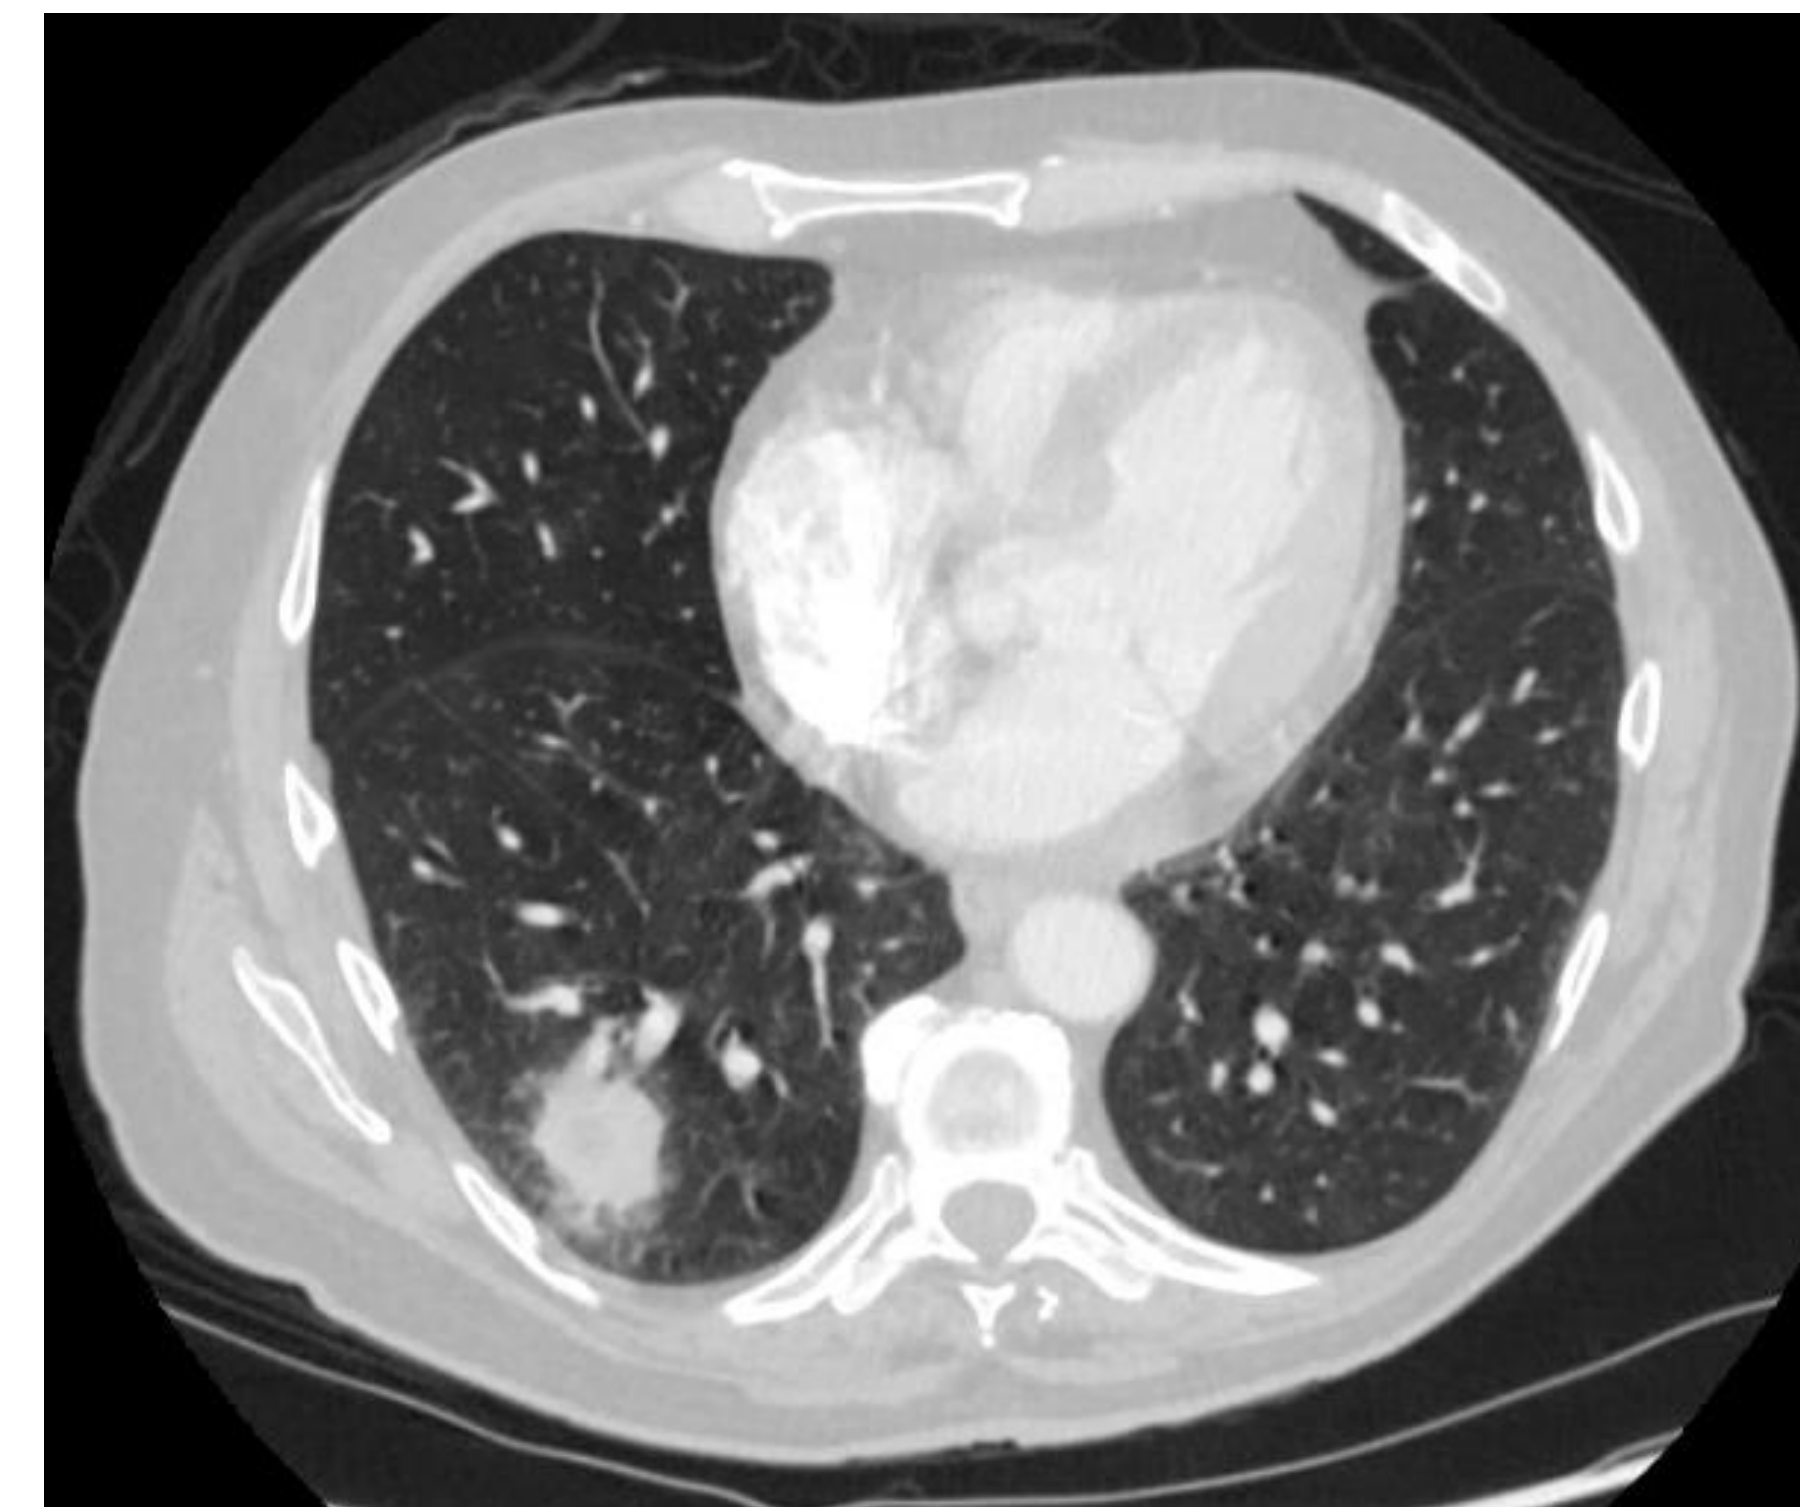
CT angiography of the chest. Notable findings include bilateral lower lung spiculated nodules measuring up to 2.9 cm, associated mediastinal and hilar lymphadenopathy, and centrilobular emphysema. No pulmonary embolism was seen. In this view, only the right lung nodule is visible.
